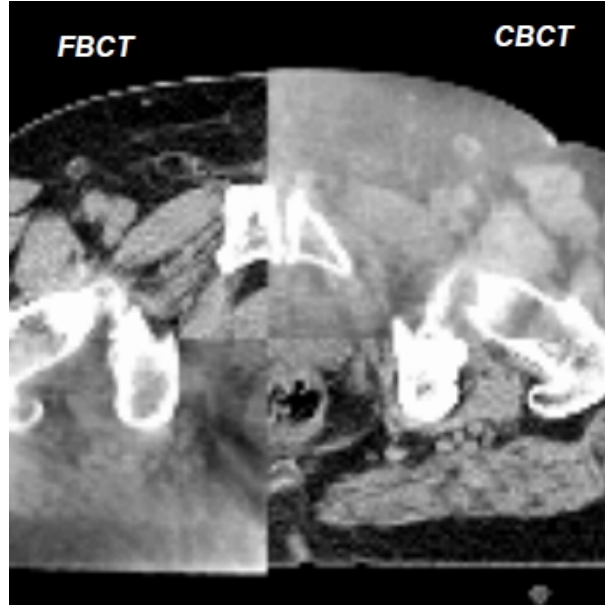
Comparison of image quality between fan-beam CT (FBCT) and cone-beam CT (CBCT) for a pelvis scan. Note the noise and poor soft tissue contrast of CBCT.
